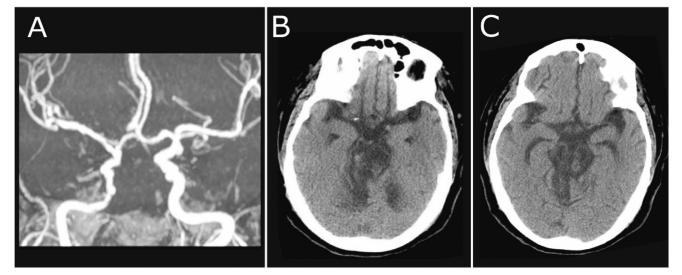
Neuroimaging studies of the stroke involving the brainstem and cerebellum. (A) Magnetic resonance angiography (MRA) showed the absence of filling in the territories of the distal intracranial vertebral and basilar arteries. (B-C) Computed tomography demonstrated infarcts in bilateral pontine structures and the cerebellum.
